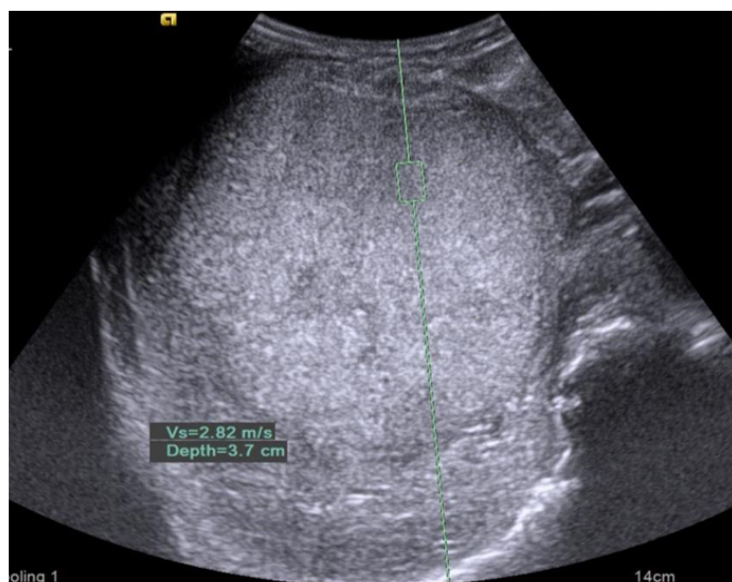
Ultrasound elastography in a case of HCC.
